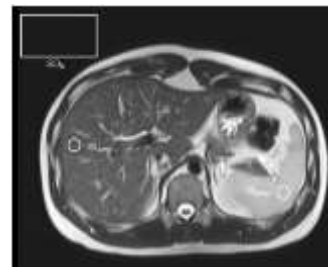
Region-of-interest (ROI) quantitative analysis of the liver MRI images.
